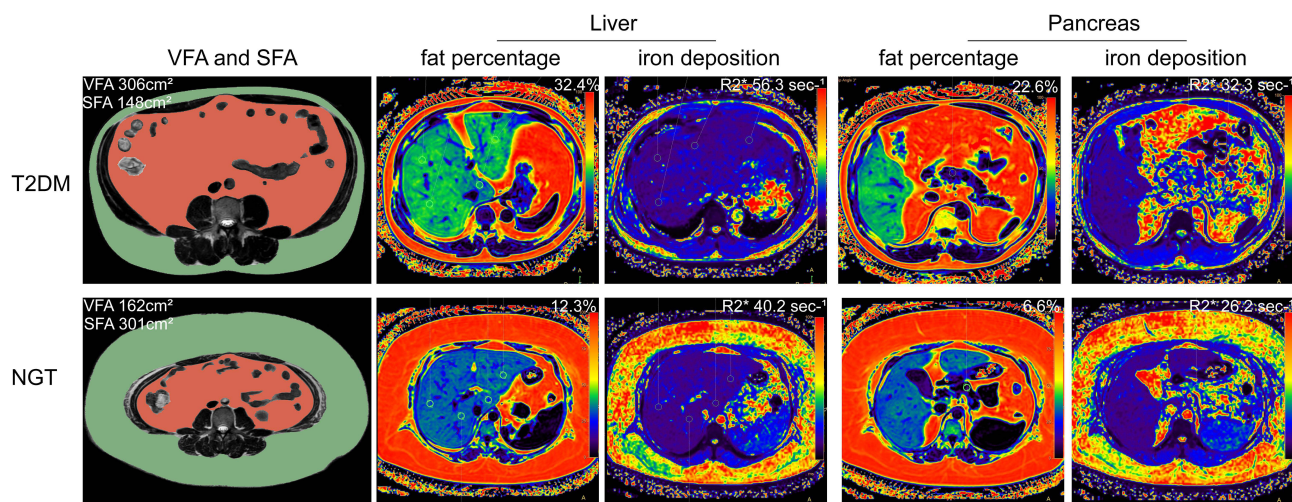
MRI images of visceral and subcutaneous fat areas, as well as liver and pancreatic fat content and iron deposition in elderly obese patients with normal glucose tolerance and type 2 diabetes.
